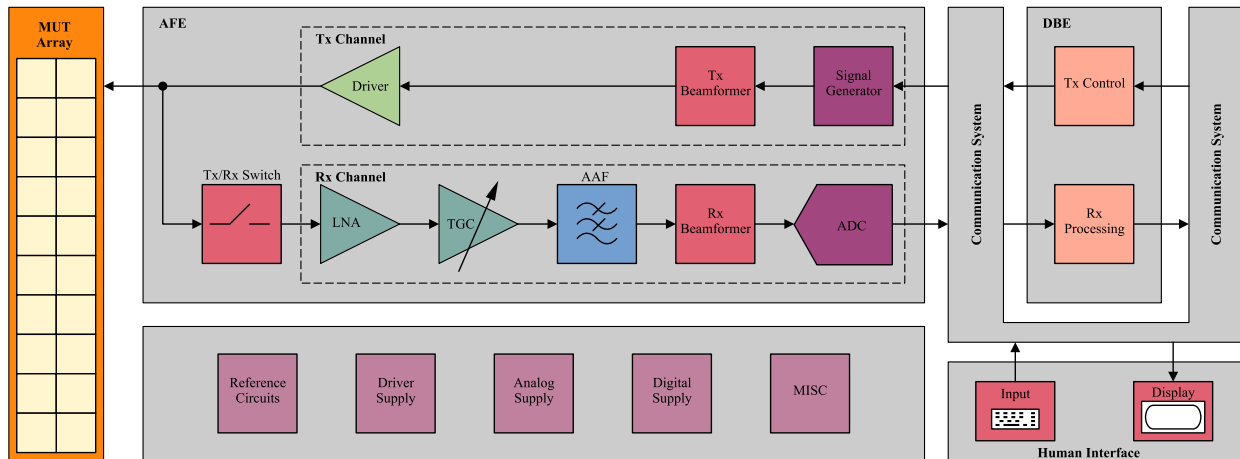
Generalized ultrasound imaging system architecture
